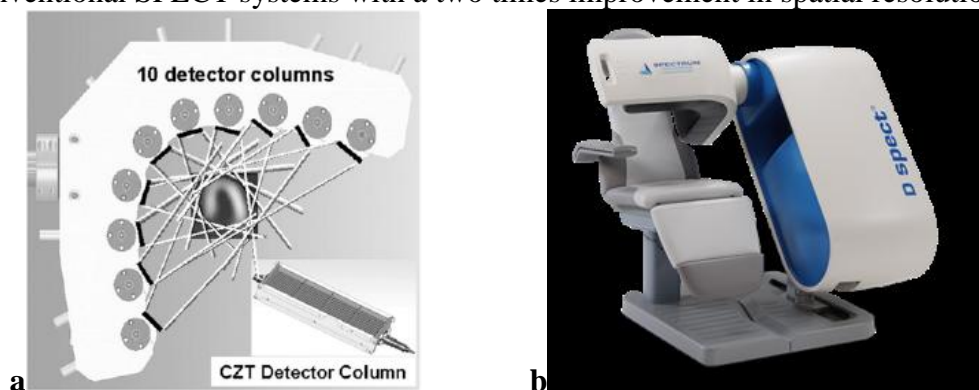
New cardiac SPECT systems.(a) Cardi Arc uses slit-slat approach to acquire projection information. D-SPECT detector head consists of 10 pixelated CZT detector columns. (b) D-SPECT cardiac scanner.
